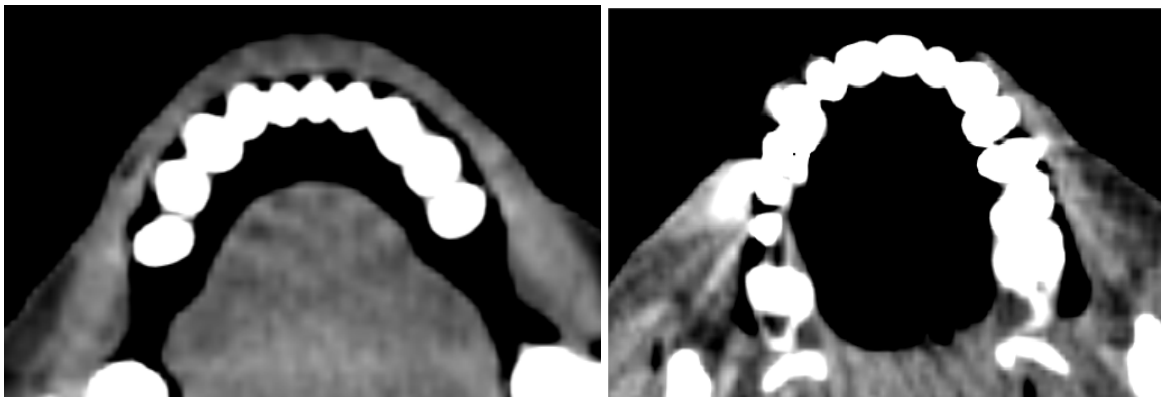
CT scan image of PMHS mandible (left) and maxilla (right) selected for the basis of a rapid prototyped model.
